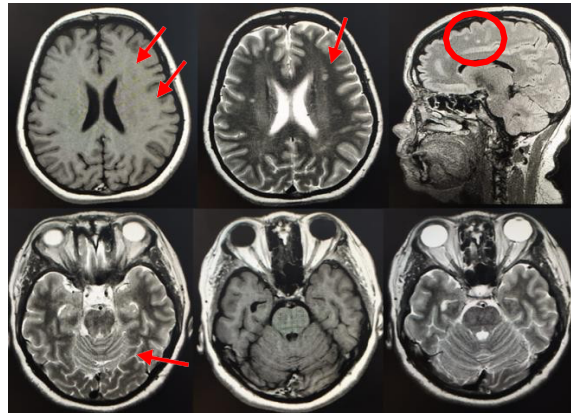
Brain MRI showed multiple lesions suspect multiple sclerosis (red arrows)
